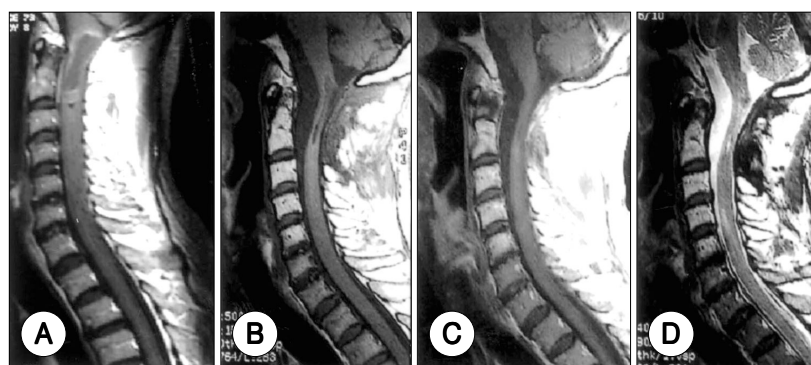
Serial MRI follow-up in an astrocytoma patient.
